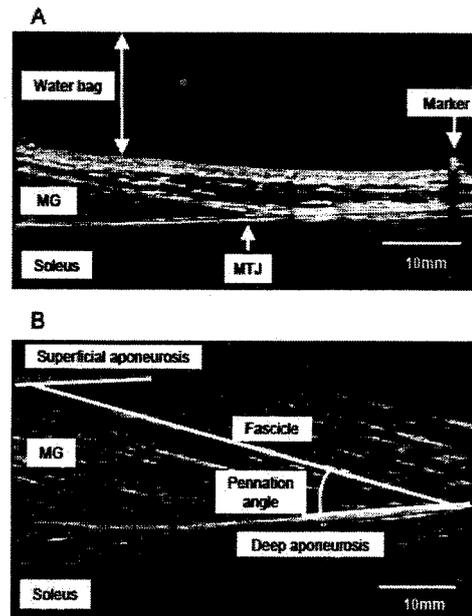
Ultrasonographic images of the MTJ (A) and the muscle belly (B). A: The coordinate of MTJ was determined as the intersection of the most distal fascicle and the deep aponeurosis. B: Fascicle length was determined as the length between the cross-points of fascicle and aponeuroses. Pennation angle was defined as the angle between the line of fascicle and deep aponeurosis.
